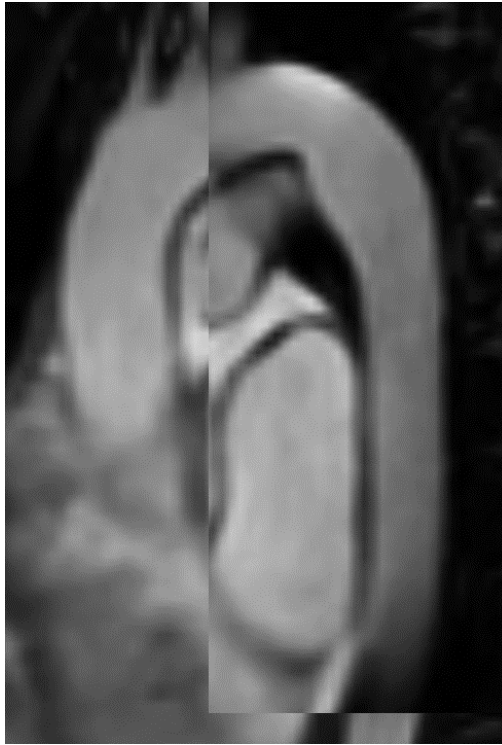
Visualization of S2 aorta with MRI using Mass.
